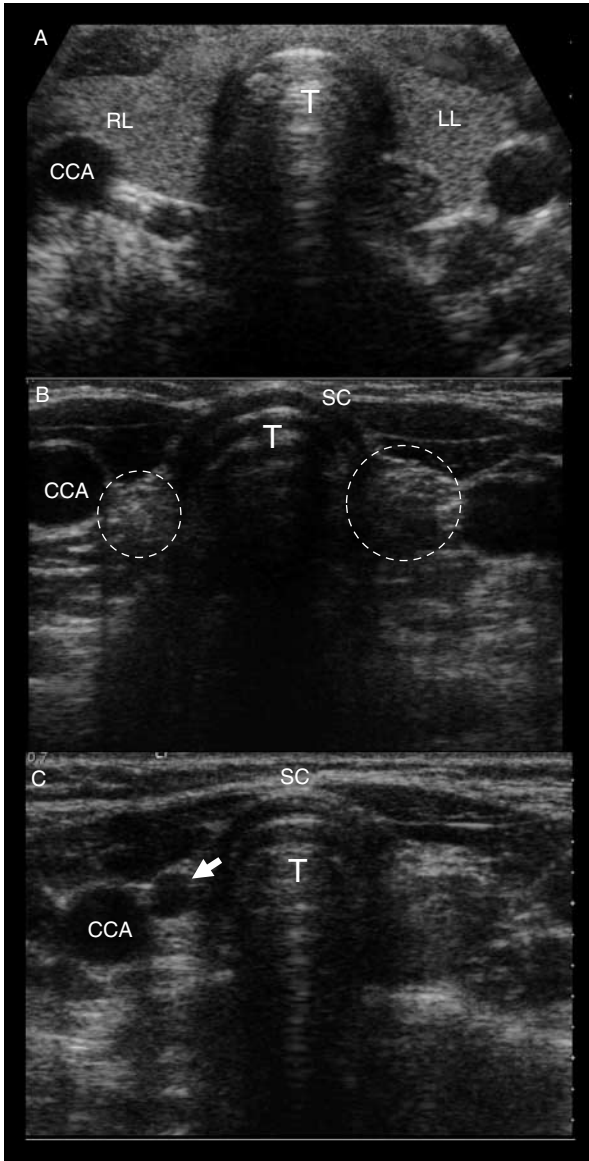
The transverse section of thyroid area at ultrasonography showing normal thyroid gland as right (RL) and left lobes (LL) at panel A, hyperechoic structures compared with normal thyroid tissue on both sides of the trachea (shown by circle) at panel B, and cystic change (shown by arrow) at panel C in the empty thyroid area. T, trachea; CCA, common carotid artery; RL, right lobe of thyroid gland; LL, left lobe of thyroid gland; SC, subcutaneous tissue.
